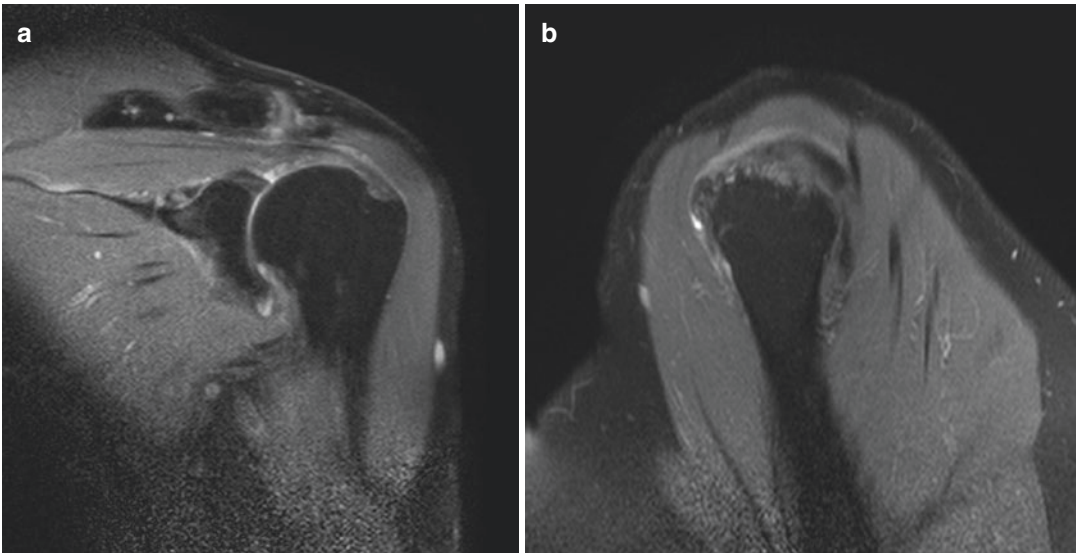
MRI of a left shoulder with an articular-sided fraying of the supraspinatus tendon. Bony erosion on the humeral head at the footprint is present. (a) Coronal view. (b) Sagittal view
